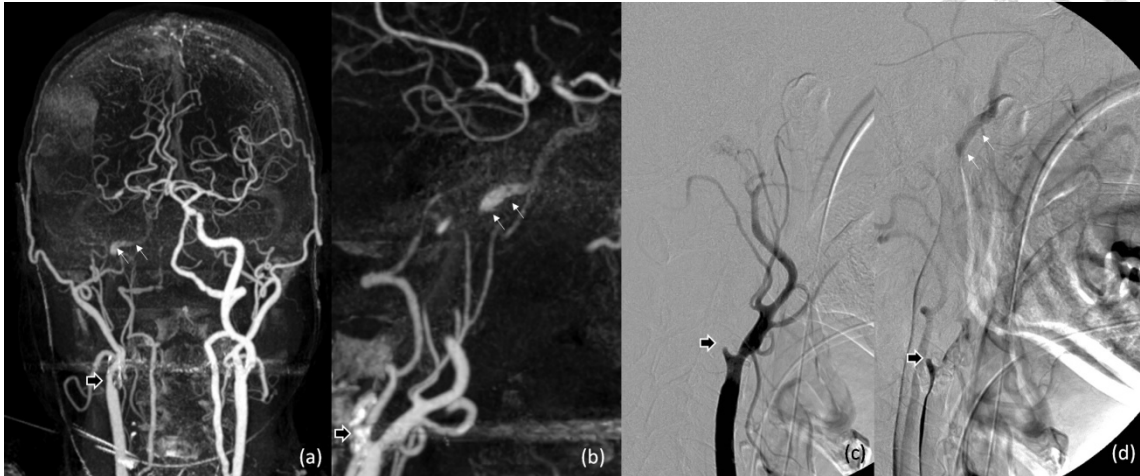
Maximal intensity projection (MIP) of hybrid CTA in frontal projection (a) and lateral projection (b). Lateral projection of right carotid angiography at early arterial phase (c) and late arterial phase (d). Black arrow indicated the occlusion point of proximal internal carotid artery (ICA). White arrows indicated reconstitution of petrous segment of ICA, which was clearly seen on hybrid CTA.
